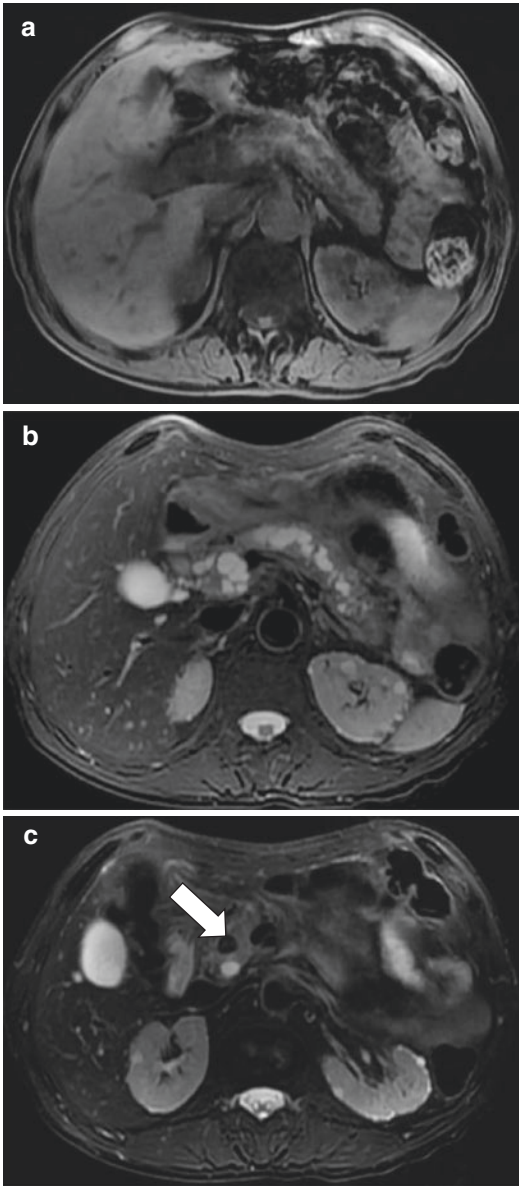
Chronic pancreatitis on MRI. Axial T₁-weighted fat-saturated spoiled gradient echo image (a) and axial T₂-weighted fat-saturated spoiled gradient echo image (b, c) demonstrate atrophy of the pancreas with a dilated bead-like appearance of the main pancreatic duct, and filling defects in the head of the pancreas (arrow)
